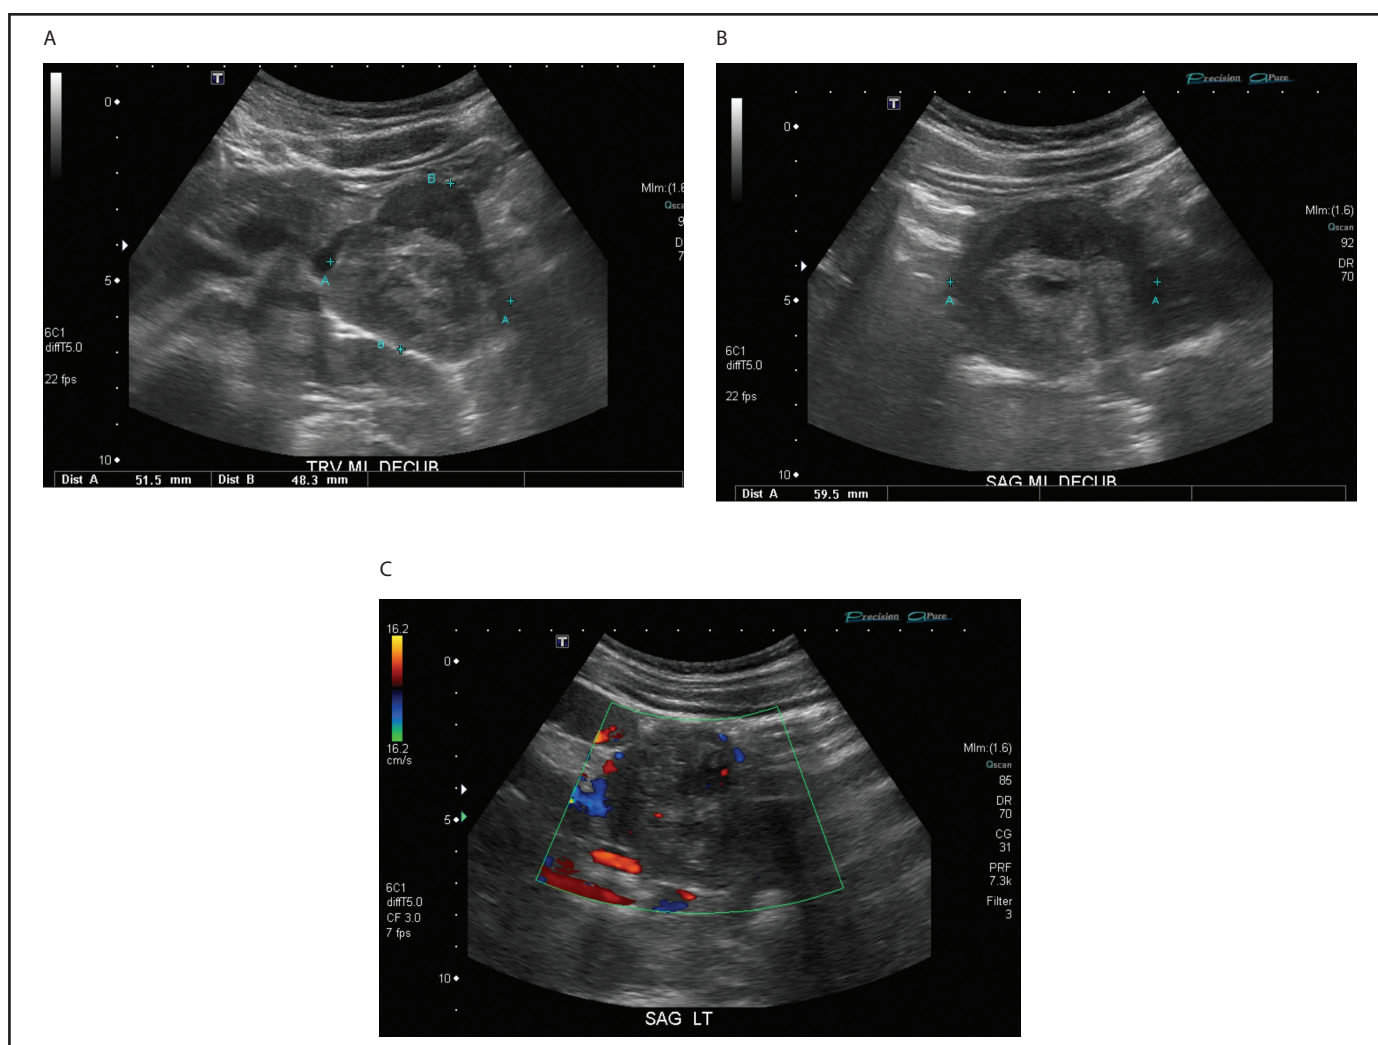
(A) Transverse: Pancreatic head/body are homogenous, pancreatic tail shows a complex lesion, suggested differential is SPEN. (B) Sagittal: Lesion in the pancreatic tail has areas of hyperechoic and hypoechoic tissue and central cystic space. (C) Sagittal: Colour Doppler shows vascularity within the solid components of the lesion.
